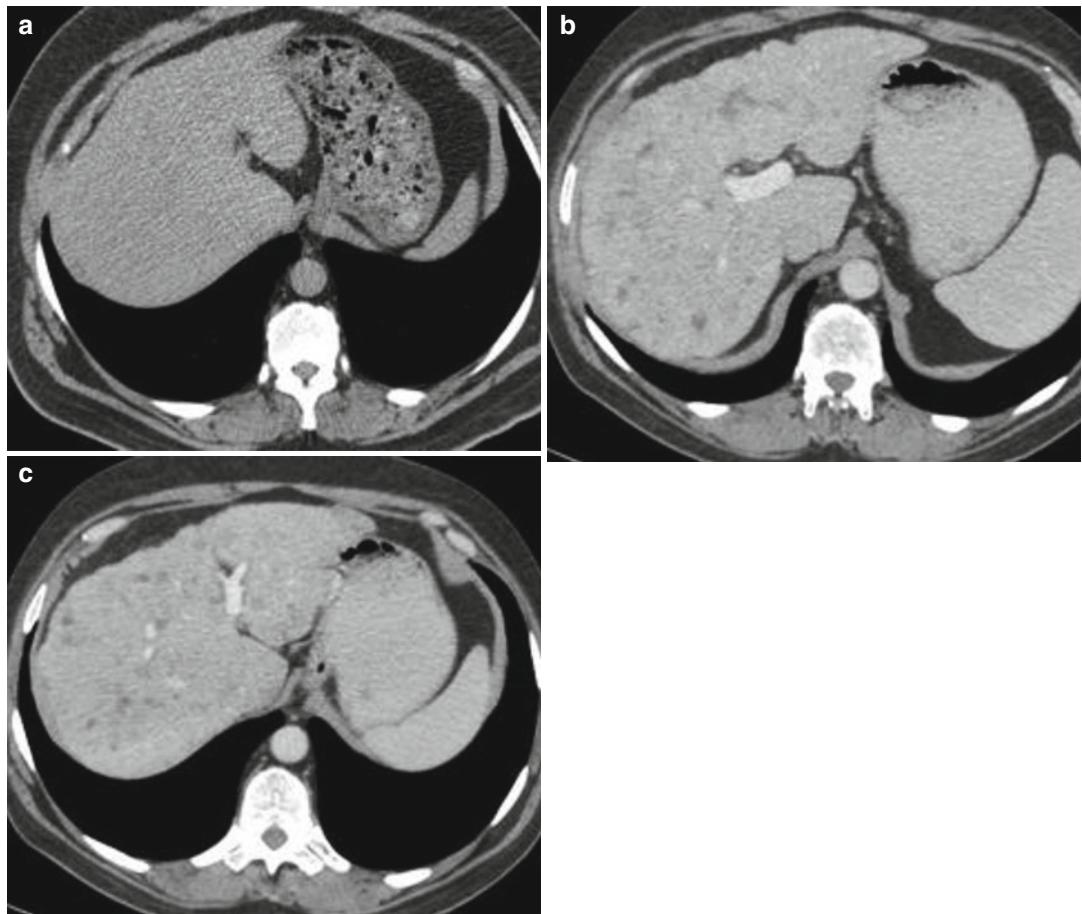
(a, b) *Chemotherapy-induced cirrhosis*: axial CT images, (a) non-contrast CT of the normal liver prior to treatment, (b) and (c) contrast-enhanced images during
